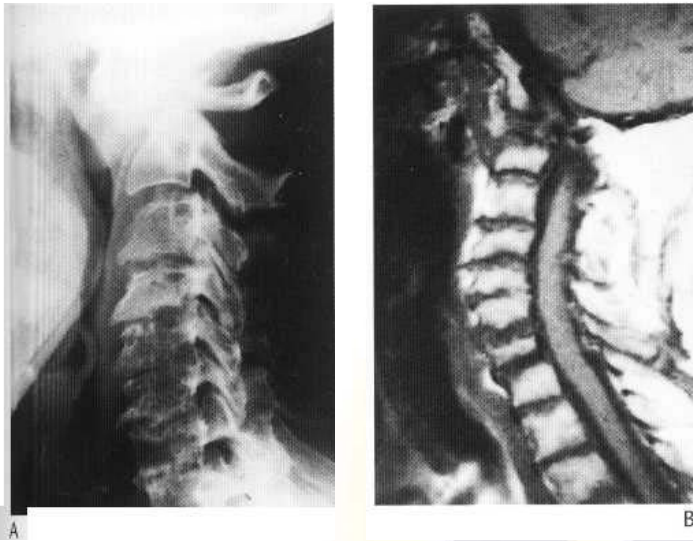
Rheumatoid arthritis of the cervical spine. (A) The plain film shows subluxation of C1 and loss of the odontoid peg. The disc spaces from C3 down are narrowed and the end-plates irregular and eroded. Fusion is demonstrated at C5/6 and C7/T1 levels. There is no soft-tissue swelling, but deformity results from the forward subluxation of C1 upon C2. (B) In the same patient the sagittal T-weighted MR sequence demonstrates that the odontoid peg is no longer visible. End-plate irregularity is again demonstrated with narrowing of disc spaces.
